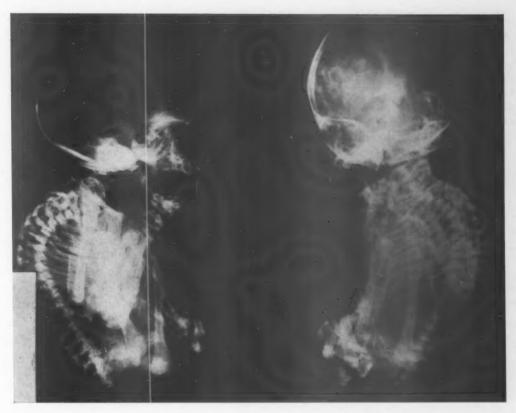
Roentgenogram of the removed lithopedion showing the excellent preservation of the fetal skeleton in spite of 13 years' incarceration.
